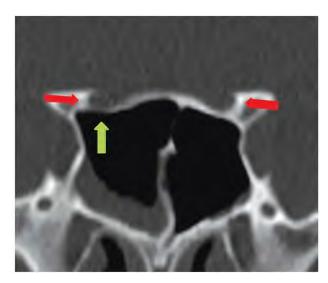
Coronal CT images showing bilateral type 1 op c nerve canals (red arrows). The canal is seen at the superior wall of the sphenoid sinuses with no canal indenta on on the sinus cavity. Right side shows canal floor dehiscence (green arrow).
